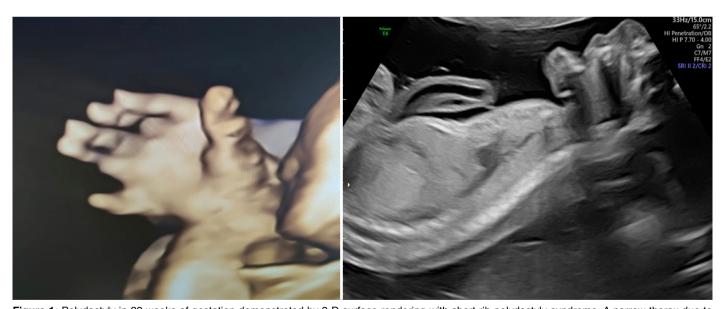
Polydactyly in 22 weeks of gestation demonstrated by 3-D surface rendering with short rib-polydactyly syndrome. A narrow thorax due to short ribs was shown in 2-D ultrasonography.
